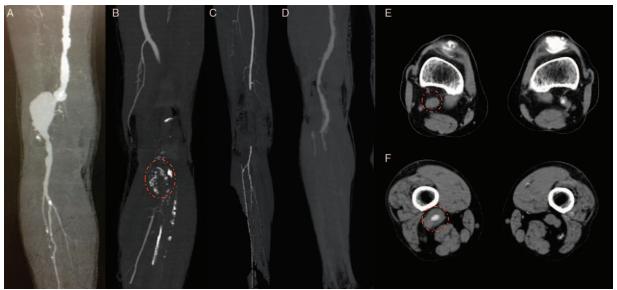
Thrombosed popliteal artery aneurysms. (A) A typical popliteal artery aneurysm with patent vessels was revealed by computed tomography angiography (CTA) three-dimensional reconstruction. (B) Pre-operative CTA three-dimensional reconstruction showed only an interrupted popliteal artery and the calcified aneurysm wall (red circle) in patient 16. (C) No sign of the popliteal artery aneurysm (PAA) but an interrupted popliteal artery was revealed by pre-operative CTA three-dimensional reconstruction in patient 20. (D) No signs of the PAA, but occluded run-off vessels were revealed by pre-operative CTA three-dimensional reconstruction in patient 10. (E and F) Cross-sectional images of CTA in patient 10 showed a thrombosed PAA (red circle).
